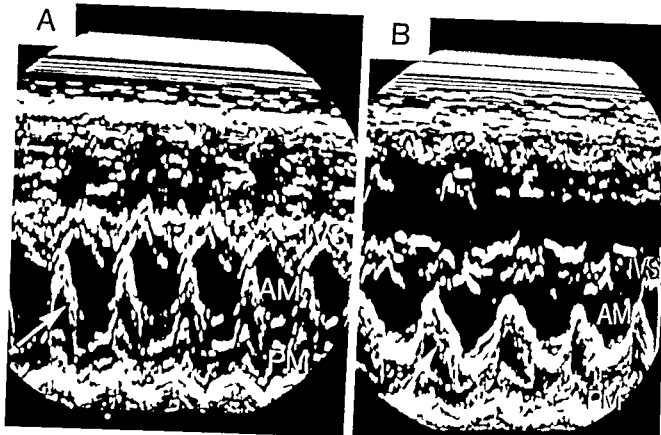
Echocardiogram obtained from patient no. 1 on day 1 (A) and day 7 (B) with the transducer directed towards the mitral valve. The anterior structures are at the top of the recording. The ultrasonic beam passes the right ventricle, the interventricular septum (IVS) and the left ventricle. In the left ventricle the echoes from
